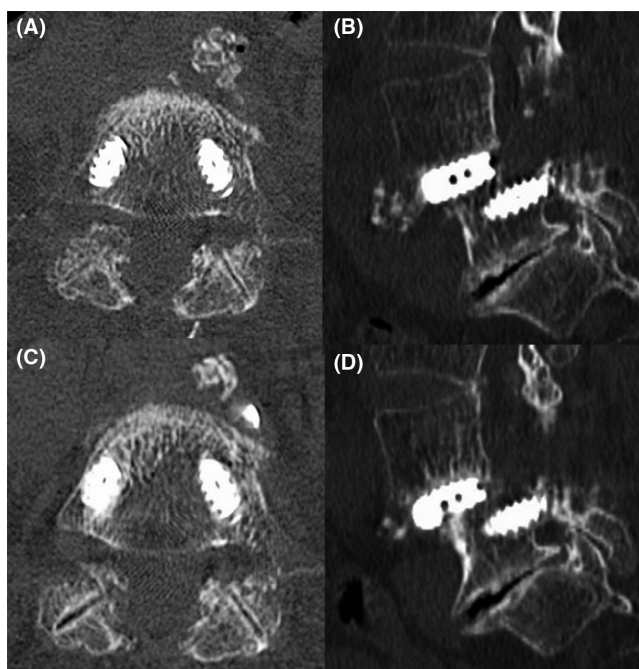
Postoperative plain CT (A: axial image, B: sagittal image) of case 2 showed a displaced grafted bone anterior to the lumbar vertebral body. At 1.5 years Postoperative plain CT (C: axial image, D: sagittal image) of case 2 showed that the allograft bone had reduced.
